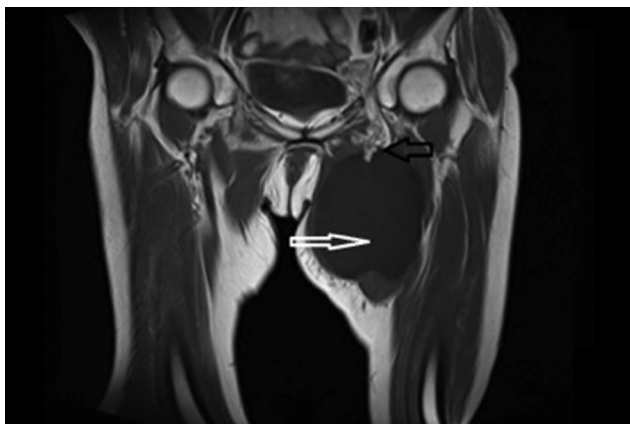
Coronal T1-weighted MR image: Herniation of the omental fat (black arrow) through the left obturator canal. Fluid collection localized distal to the herniated tissue (white arrow).
